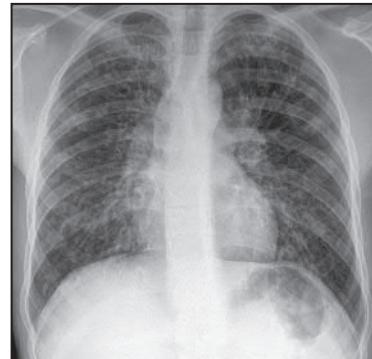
A chest X-ray in cystic fibrosis showing hyperinflation, marked peribronchial shadowing, bronchial wall thickening and ring shadows.
